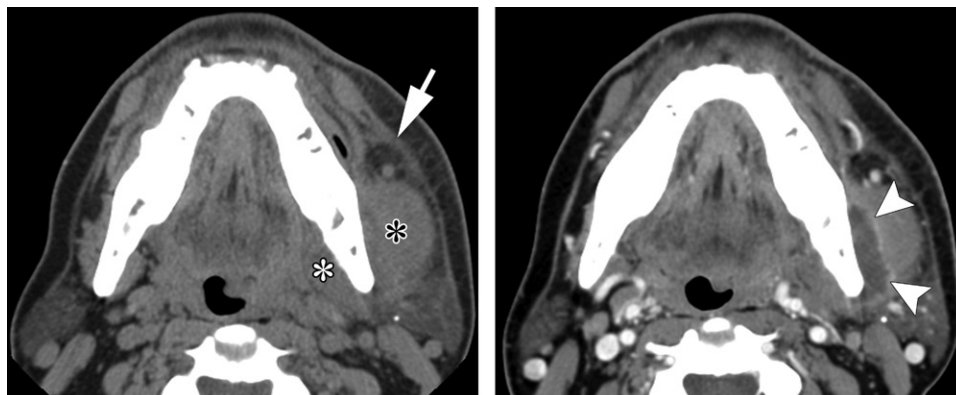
Periodontal abscess in a 50-year-old man. (a) Axial nonenhanced CT image shows asymmetric soft-tissue thickening (white *) medial to the left mandibular ramus, as well as thickening of the left masseter muscle (black *). Owing to the lack of contrast enhancement, an abscess cannot be discerned. Note the thickening of the left platysma muscle (arrow). (b) Twelve hours later, the CT examination was repeated with intravenous contrast material administration, and the abscess (arrowheads) could be delineated between the mandibular ramus and masseter muscle.
